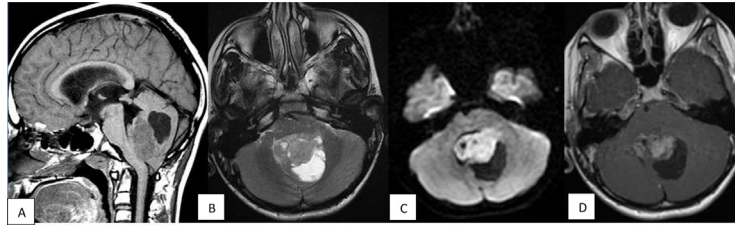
Encephalic MRI: Sagittal T1 (A), Axial T2 (B) showed a vermian tumor, hypoisignal on T1 hypersignal on T2 and on diffusion (C) enhancing after the injection of gadolinium (D).
